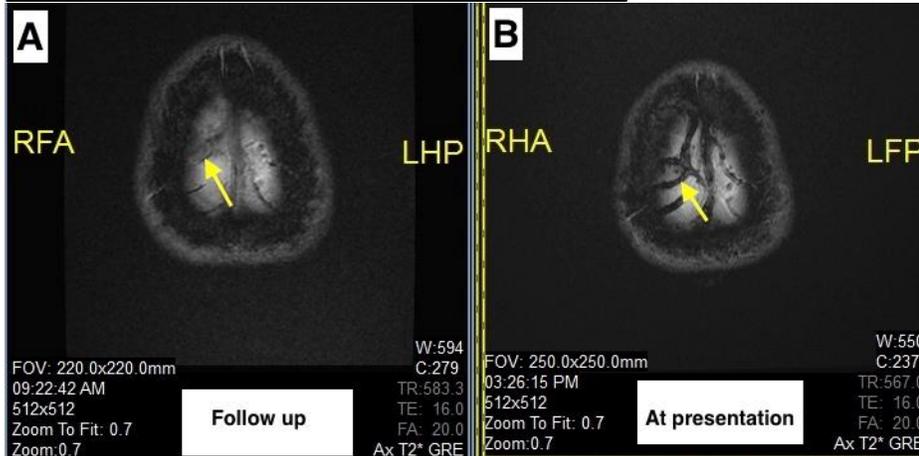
A: Echo gradient MRI of the brain in follow up visit after three month showing normal caliber cortical veins. B: Echo gradient MRI of the brain at presentation showing dilated cortical veins (B).
